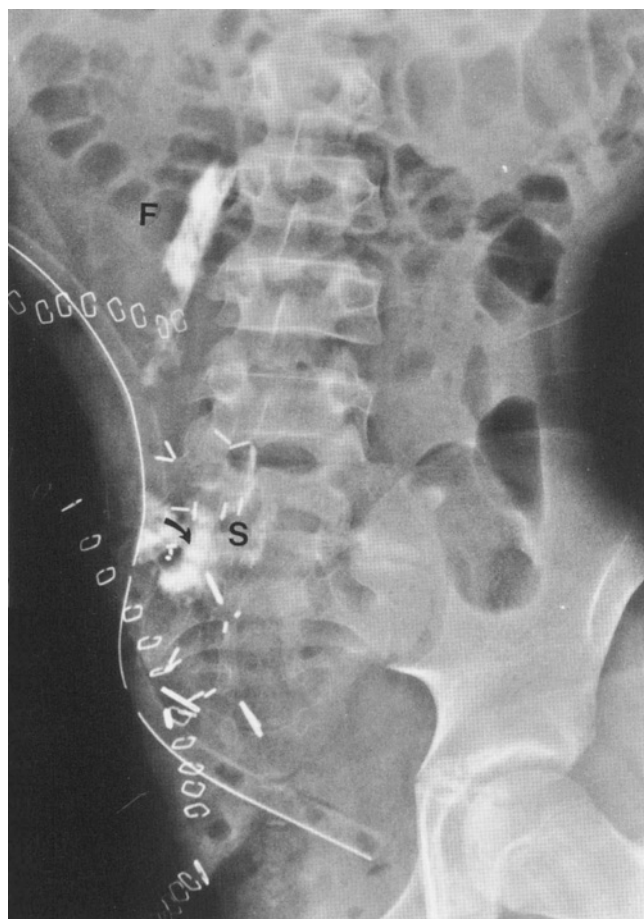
Postoperative radiograph of an extended hemipelvectomy (note the sacral alar is absent) with contrast injection of the marcaine catheters that were placed perineurally along the femoral nerve sheath as well as the lumbar sacral plexus. This has been our standard method of postoperative pain control. Perineural marcaine catheters can reduce the need for morphine by approximately 80–90%. They are left in place for 3–5 days. F = femoral nerve; S = sciatic nerve; arrow indicates renografin (contrast) in sciatic sheath.
